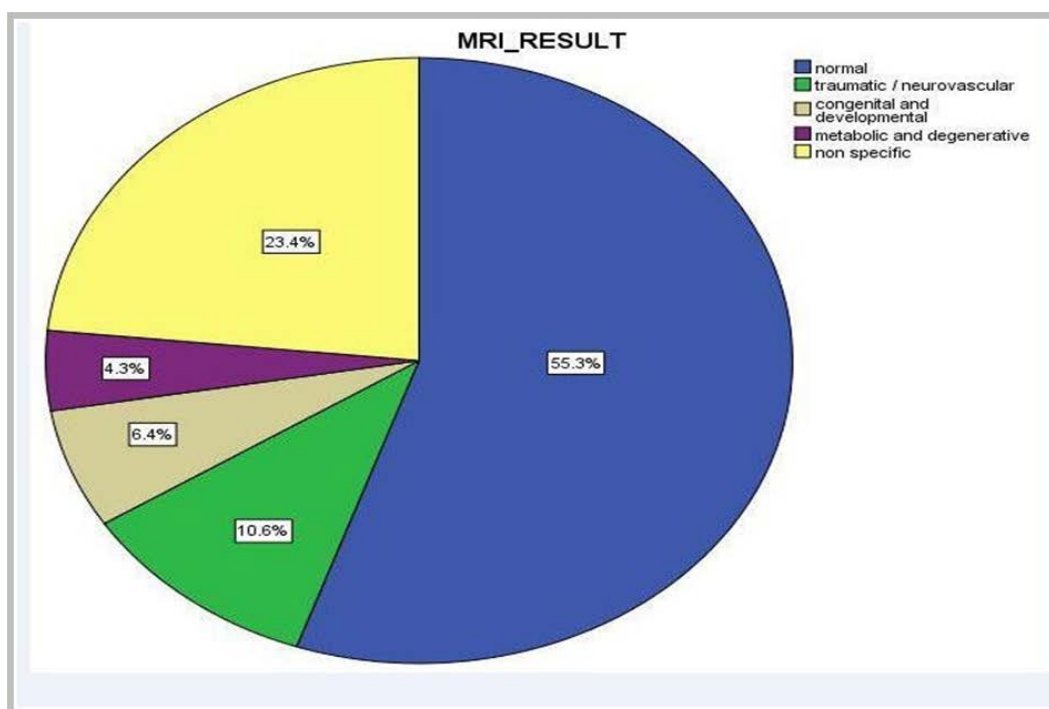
Categories of MRI results
